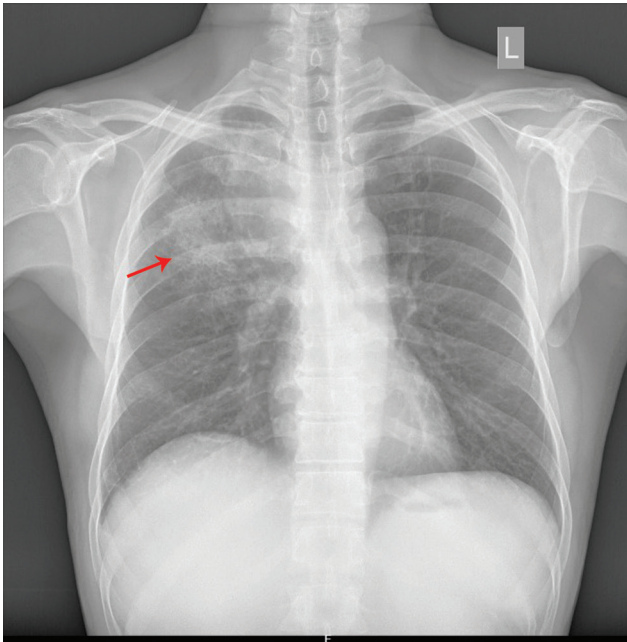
Chest X-ray showing illdefined nonhomogenous consolidation in right upper zone.
